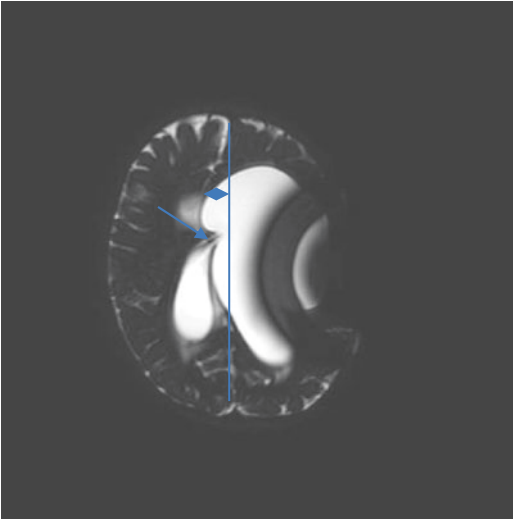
MRI image prior to surgery. Arrow indicating VP shunt entering left ventricle. Marked hydrocephalus, large porencephalic cavity resulting in mass effect on the contralateral right ventricle with left to right midline shift. Line in the middle indicating midline and shift
